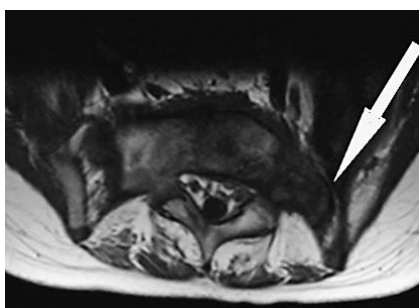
T2 MRI transversal view (S1)
